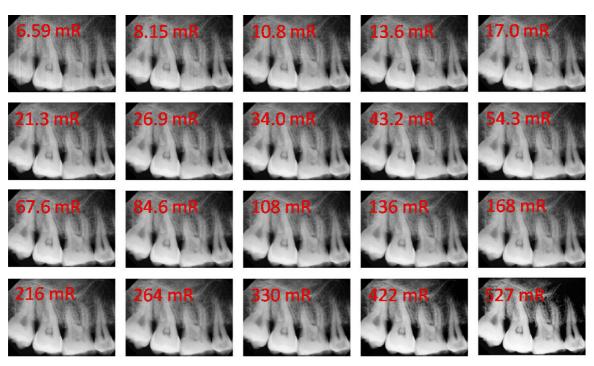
Radiographs of a human maxilla at incrementally increasing exposures over a range of 20 exposures. mR, milliRoentgens.
